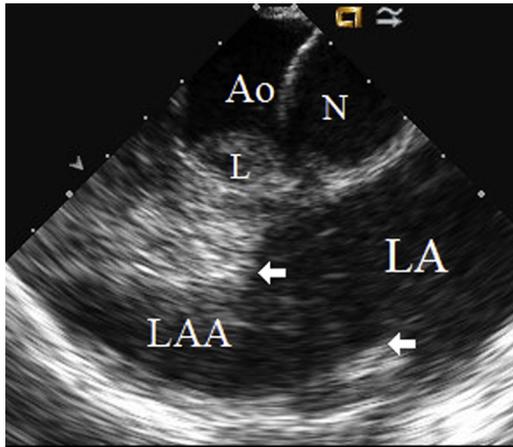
Intracardiac Echocardiographic Imaging of LAA With a Windsack-Like Body
